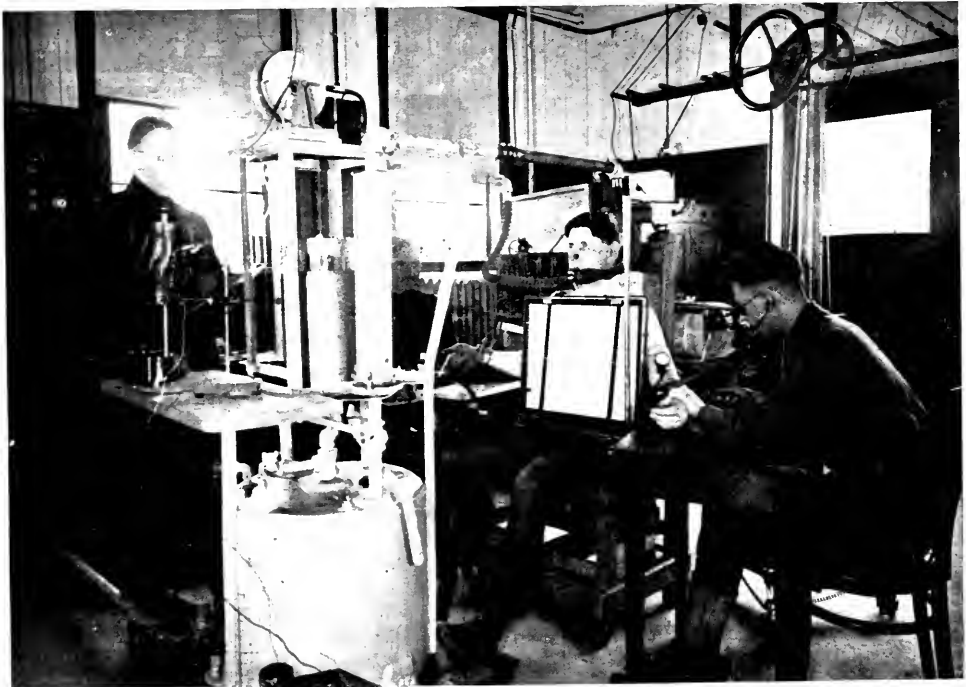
ROENTGENOGRAM BEING TAKEN IN CONJUNCTION WITH REBREATHING, ETC.
